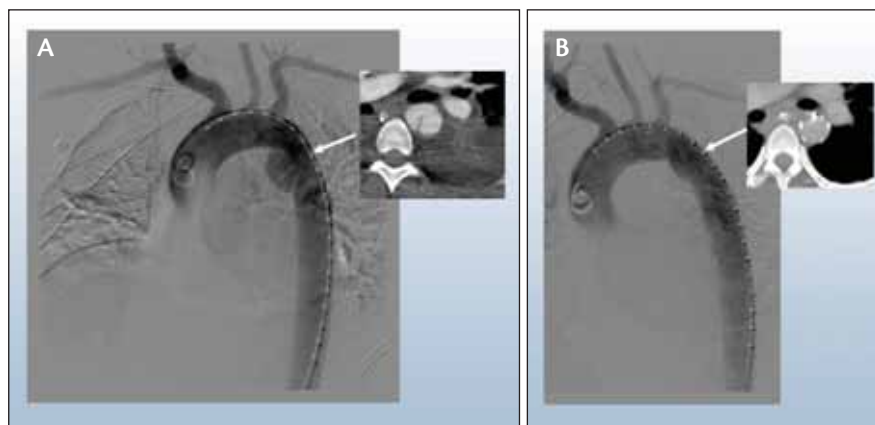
Preintervention angiogram and CT of an acute aortic traumatic injury (A) and 2-week postprocedure angiogram and CT of the aorta after placement of the Valiant thoracic device (B).
